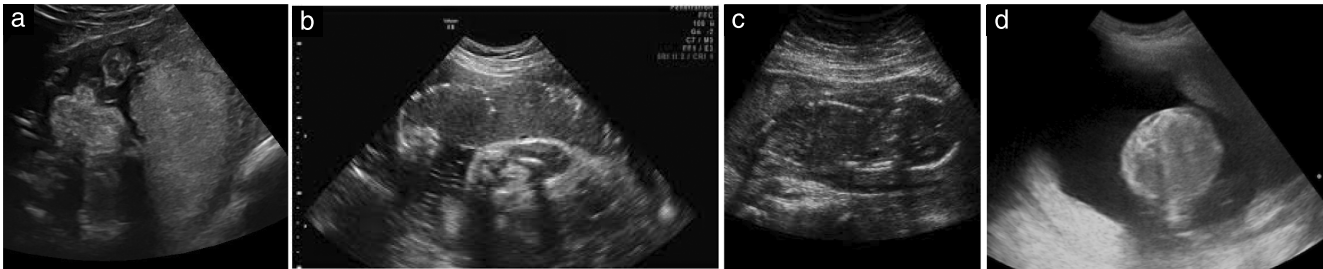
Ultrasonographic placental/amniotic fluid abnormalities typical of CMV infection vary, and include: placentomegaly (a), placental calcifications (b), oligohydramnios (c) and polyhydramnios (d).
